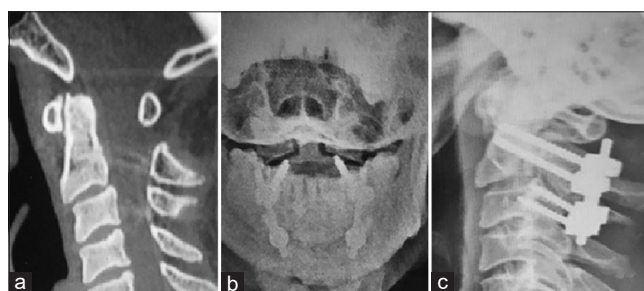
(a) Lateral cervical spine X-ray showing unstable hangman's fracture with mild listhesis and associated fracture of odontoid. (b) Cervical spine AP view showing posterior fracture fixation with good reduction and alignment. (c) Cervical spine lateral view showing posterior fracture fixation with fracture and listhesis reduction
